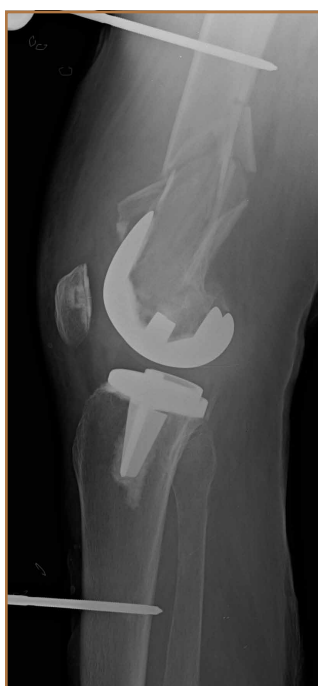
Lateral radiograph of knee immediately after application of spanning uniplanar external fixator.
